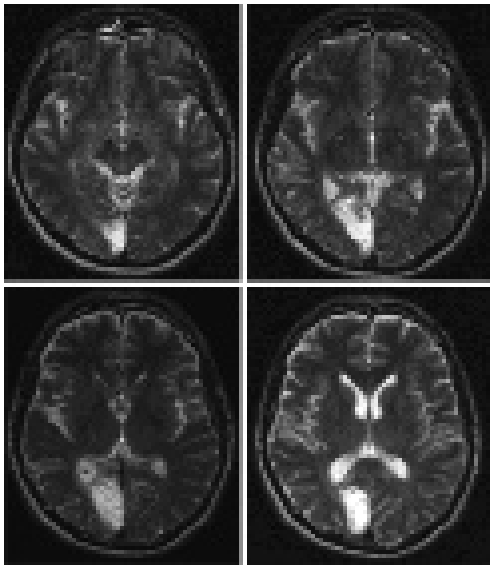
These T2-weighted images show a right occipital infarction that seems to correspond to posterior cerebral artery territory.
